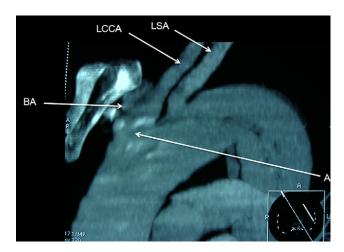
Preoperative saggital CT scan demonstrating Type B dissection (A) extending to the left common carotid (LCCA) and necessitating overstenting of all supra-aortic vessels. BA- Brachiocephalic artery, LSA- Left subclavian artery.
